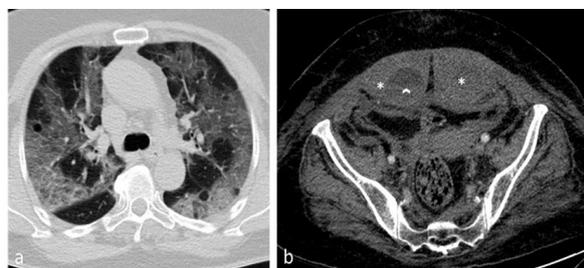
Rectus sheath hematoma in a 69-year-old woman with COVID-19 pneumonia. Axial chest CT (a) demonstrates confluent geographic areas of ground-glass opacity with the dominant peripheral distribution. Axial CT (b) shows bilateral rectus sheath hematoma (white asterisks) with fluid-fluid level formation (arrowhead) on the right side.
